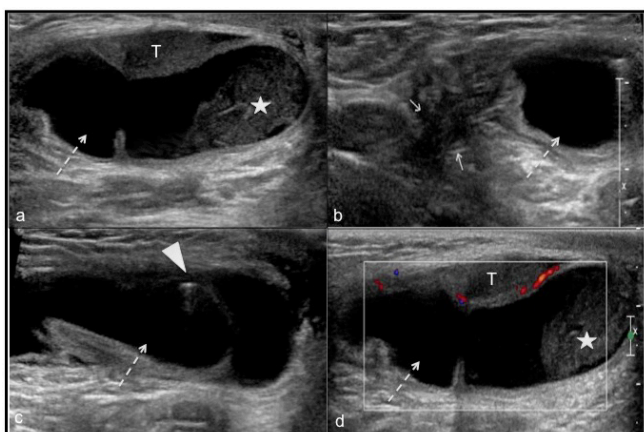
(a,b,c,d). Ultrasound images of the patient's right scrotum reveal a dilated loop of bowel (dashed arrow) extending from a narrow opening (arrow) in the right inguinal canal to the right scrotum adjacent to the normal appearing right testis (T). Intraluminal gas (arrowhead) and debris (asterisk) are seen within the bowel loop. Intramural vascularity of the bowel wall is preserved. Appearance is consistent with an obstructed right inguinal hernia containing a loop of bowel.
